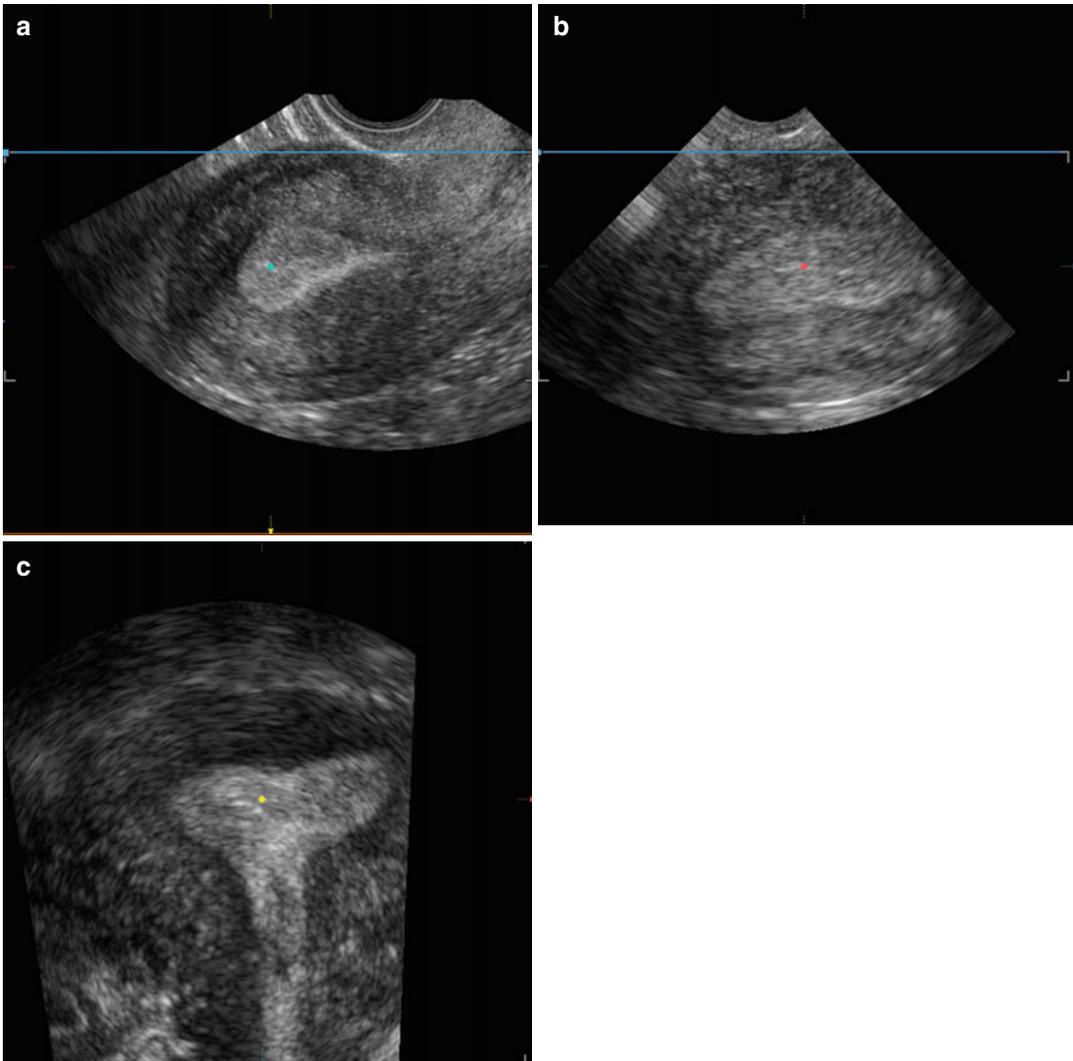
transvaginal ultrasound of a T-shaped uterus in the sagittal plane (a), the transversal plane (b) and the coronal plane (c)
